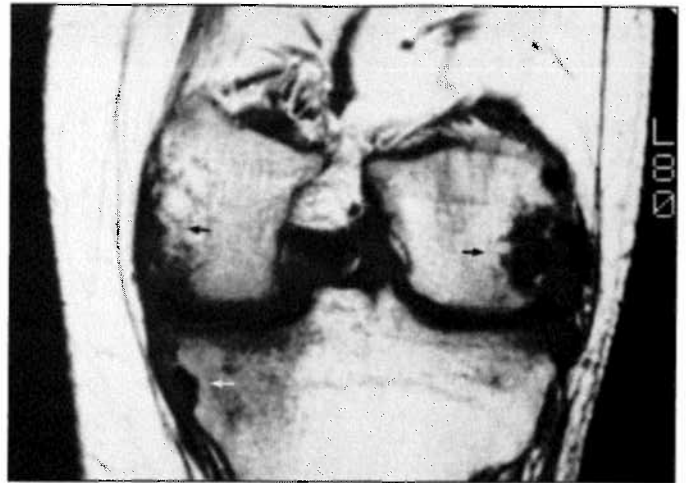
and 12 Coronal T1 and MPGR weighted MR images of the same patient in Figure 10 demonstrate the bare area erosive changes seen in the radiograph (arrows). A large subchondral cyst is identified as areas of abnormal increased signal in the tibial plateaus (arrowhead) on the MPGR image. A moderate joint effusion is present as noted by the high signal within the joint on the MPGR images.
